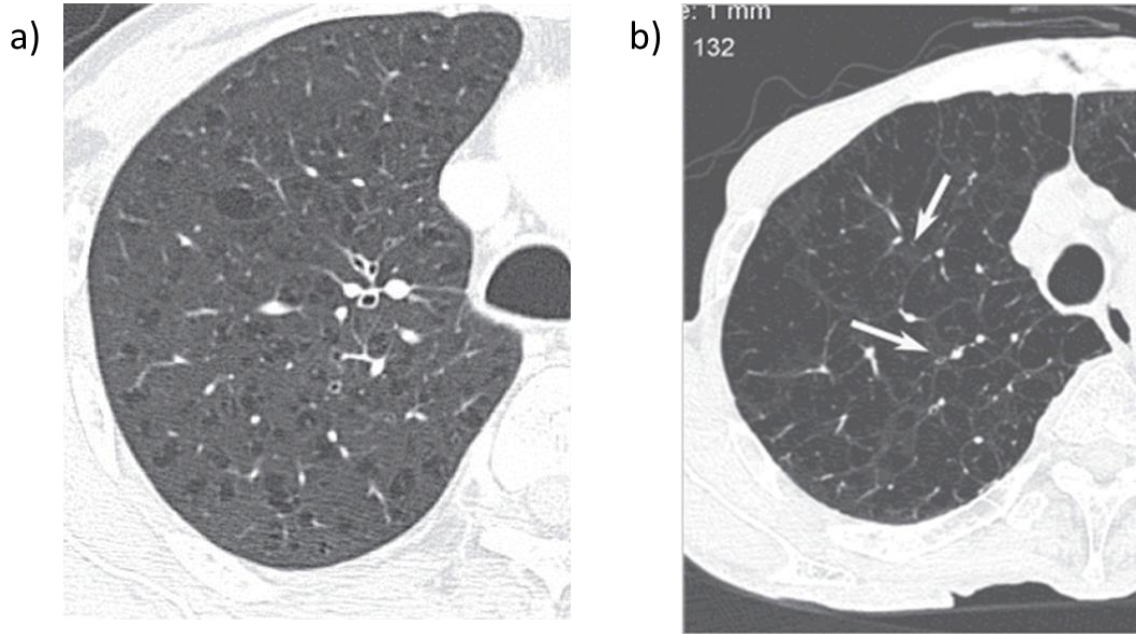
(a) Example of a HRCT of a patient with early centri-acinar emphysema (CAE) in the upper lobes, showing dilated airspaces (low attenuation areas). (b) A patient with advanced CAE, showing diffuse disease and loss of normal tissue except around small vessels (arrow). Also visible are the septal wall thickening, where normal tissue is compressed by dilated airspaces. Adapted from (161).
